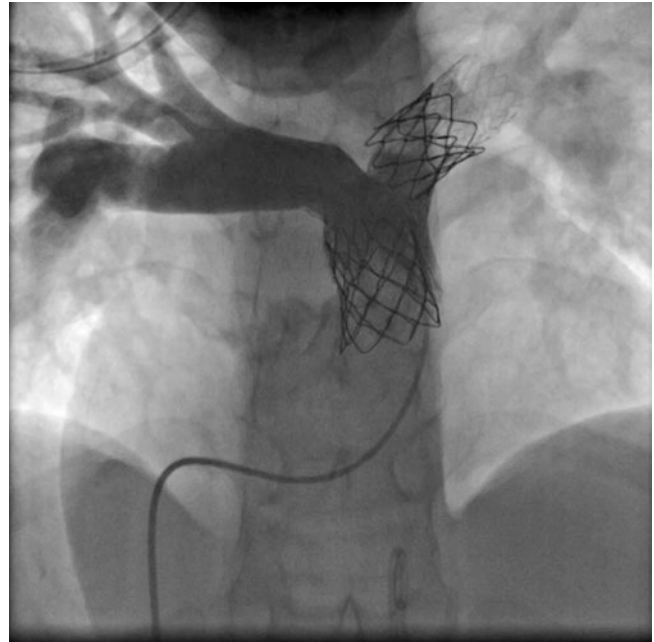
Finally, a Melody valve (Medtronic, Minneapolis, MN, USA) was implanted with a 22 mm delivery balloon. Final hemodynamics: RVP 45/3/10, PAD 30/17/21, AoP 128/72/91 and no residual pulmonary regurgitation in the MRI control study
